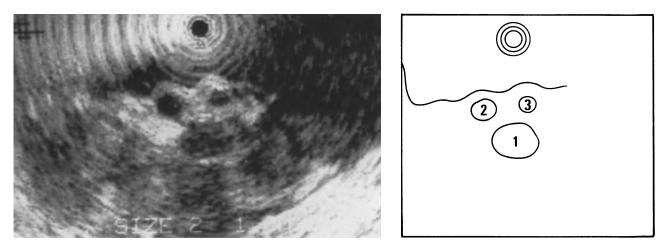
Sonographic view of the hepatoduodenal ligament. Portal vein (1), common hepatic duct (2), hepatic artery (3).
